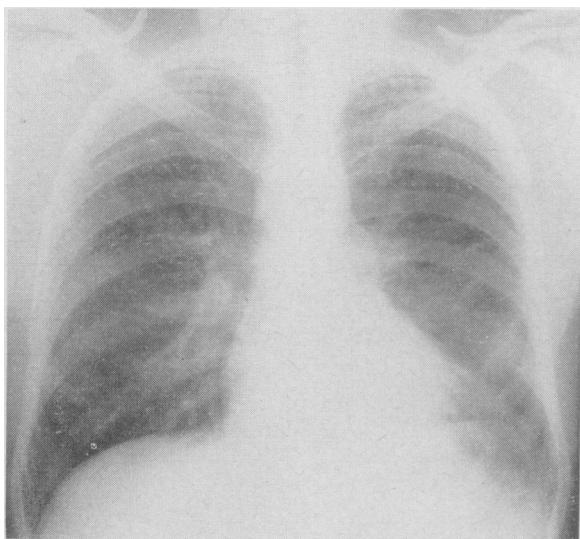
Chest radiograph after treatment.
